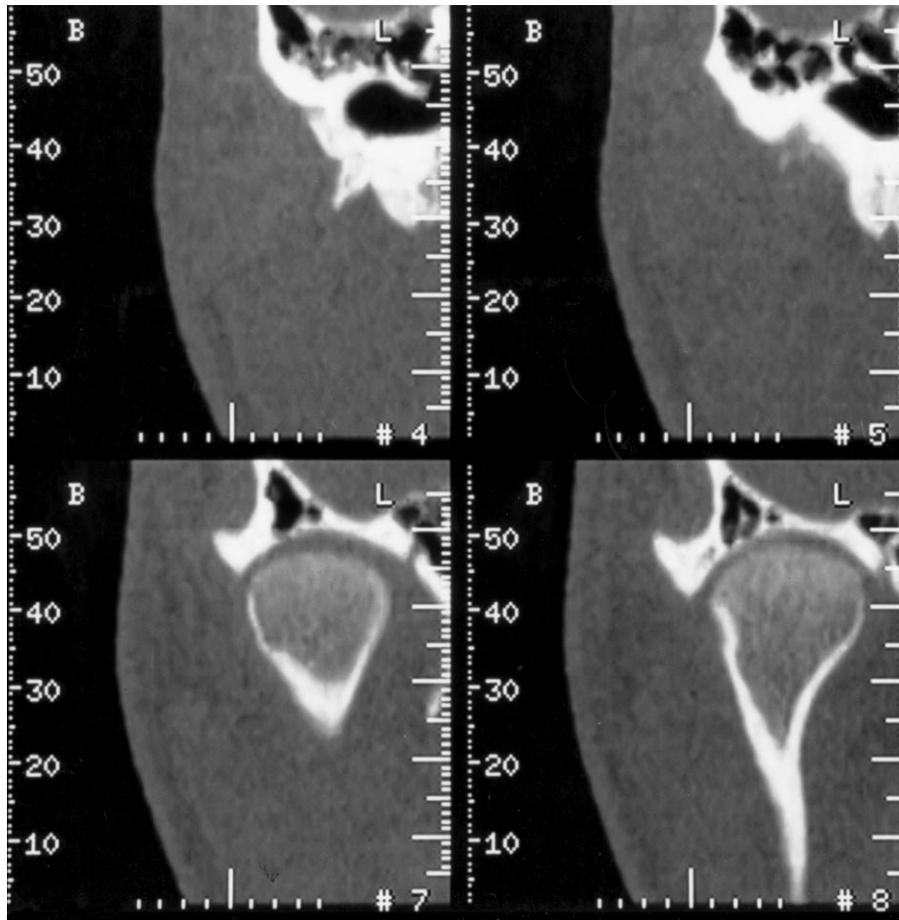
Prominent condylar head. The cross-sectional view of the DentaScan of 18-year-old man shows the prominence of the condylar head. No marginal osteophytes or joint erosion is seen. Bone scintigraphic examination revealed the condylar head had twice the tracer uptake compared to the adjacent cranium.
